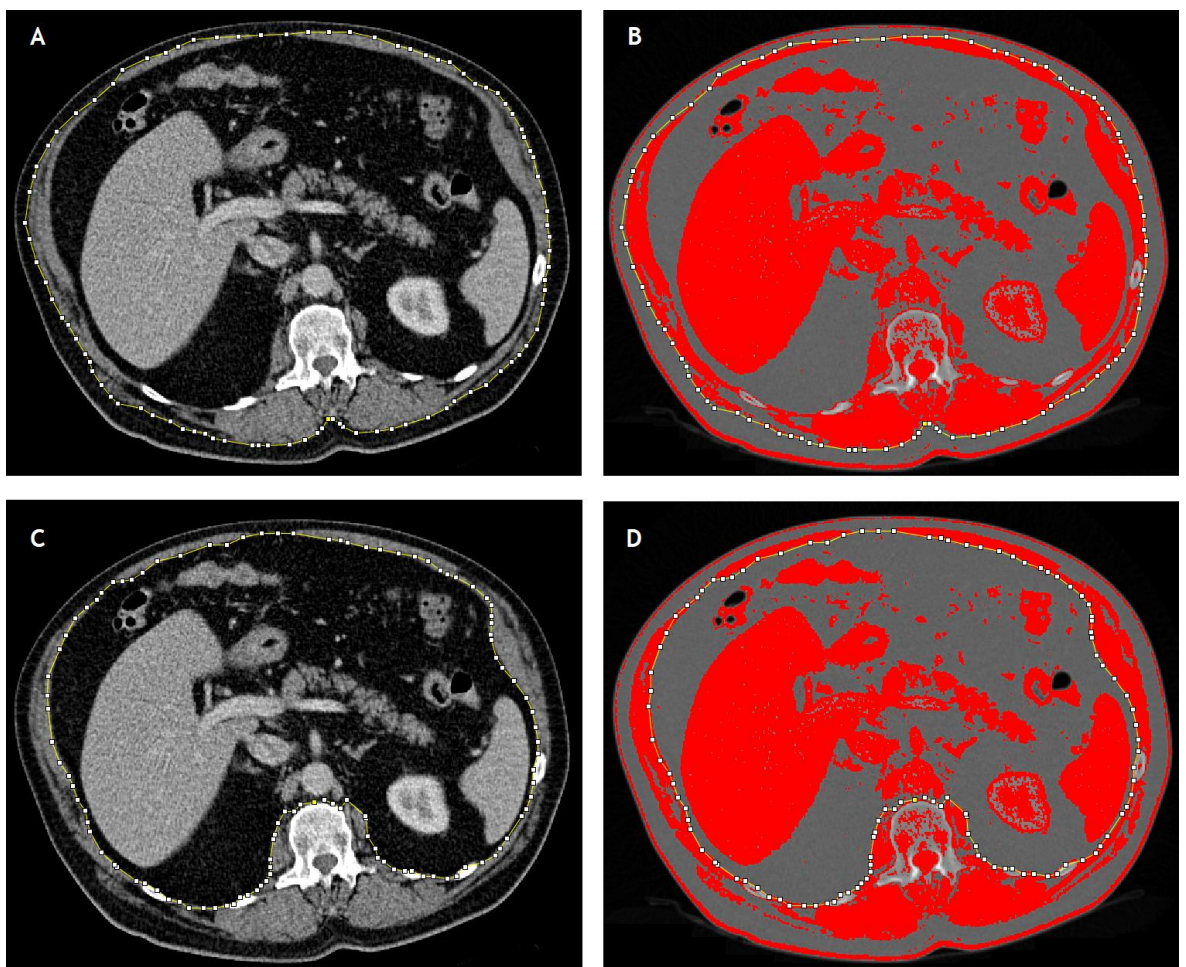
Axial slices of CT scans demonstrating the third lumbar vertebra (L3). Panel A demonstrates the delineation of the external skeletal muscle area (SMA) on ImageJ software, defined by the area included in the dotted yellow line. Panel B demonstrates the skeletal muscle threshold selection using a HU range of -29 to +150 HU. Panel C demonstrates the delineation of the internal SMA, defined by the area included in the dotted yellow line. Panel D demonstrates skeletal muscle HU threshold selection
